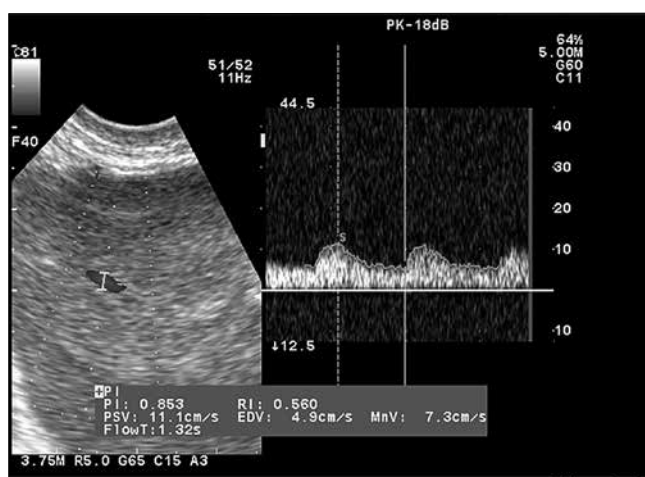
Doppler examination of 34-year-old woman with endometrioid ovarian adenocarcinoma.
